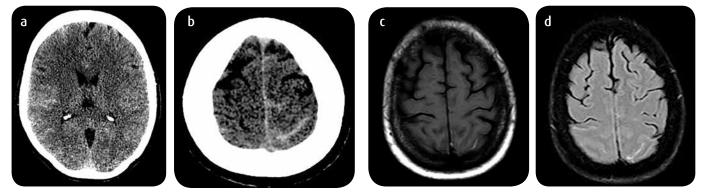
Female patient, 50 years old. Headache consultation. WFNS grade I. a and b) axial simple CT of skull: SAH, Fisher modified grade 1 of cortical pattern. Arteriography did not show aneurysms. Contrast MR was performed to rule out other causes. C) Sequences T1 and d) FLAIR: Confirm SAH without other findings. The patient did not develop vasospasm in serial transcranial Doppler controls and was discharged after 15 days of hospitalization.
